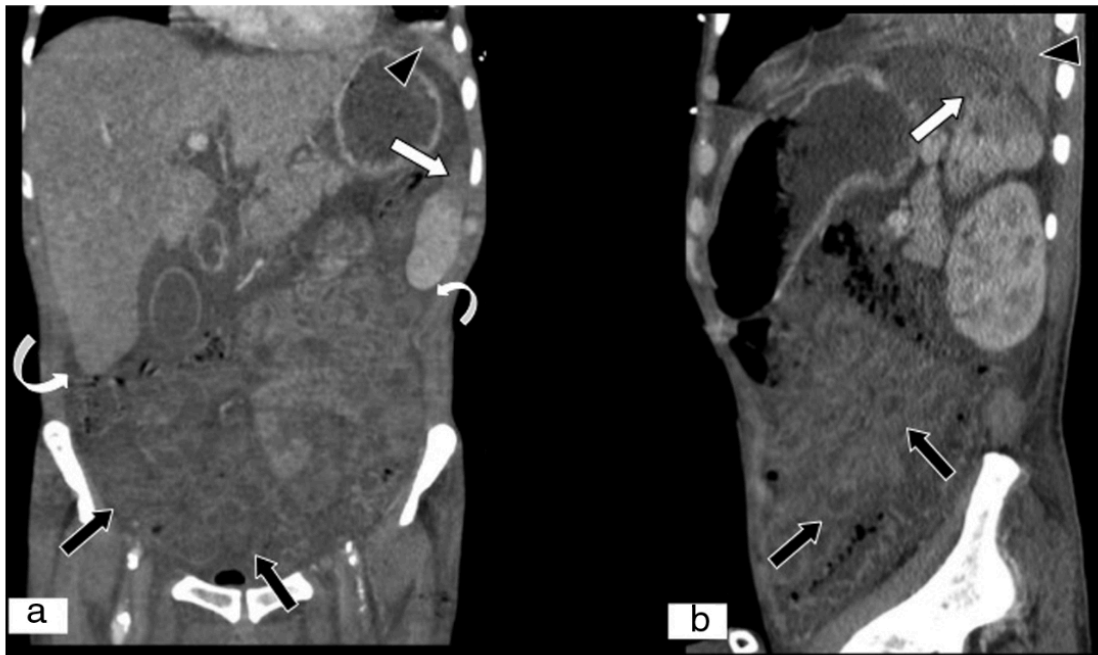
NOMI in a patient with septic shock in coronal MPR-CT (A) and sagittal MPR-CT (B)
